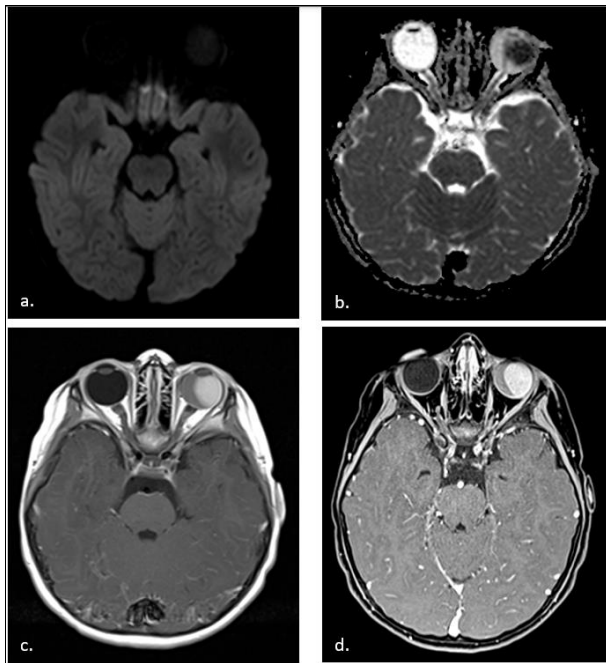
Contrast enhanced MRI. a. and b. DWI and ADC map with slight restriction, markedly hypointense in ADC map. c. T1WI axial image with contrast and d. T1WI FS axial image with contrast shows a rapidly enhancing and hypervascular lesion
